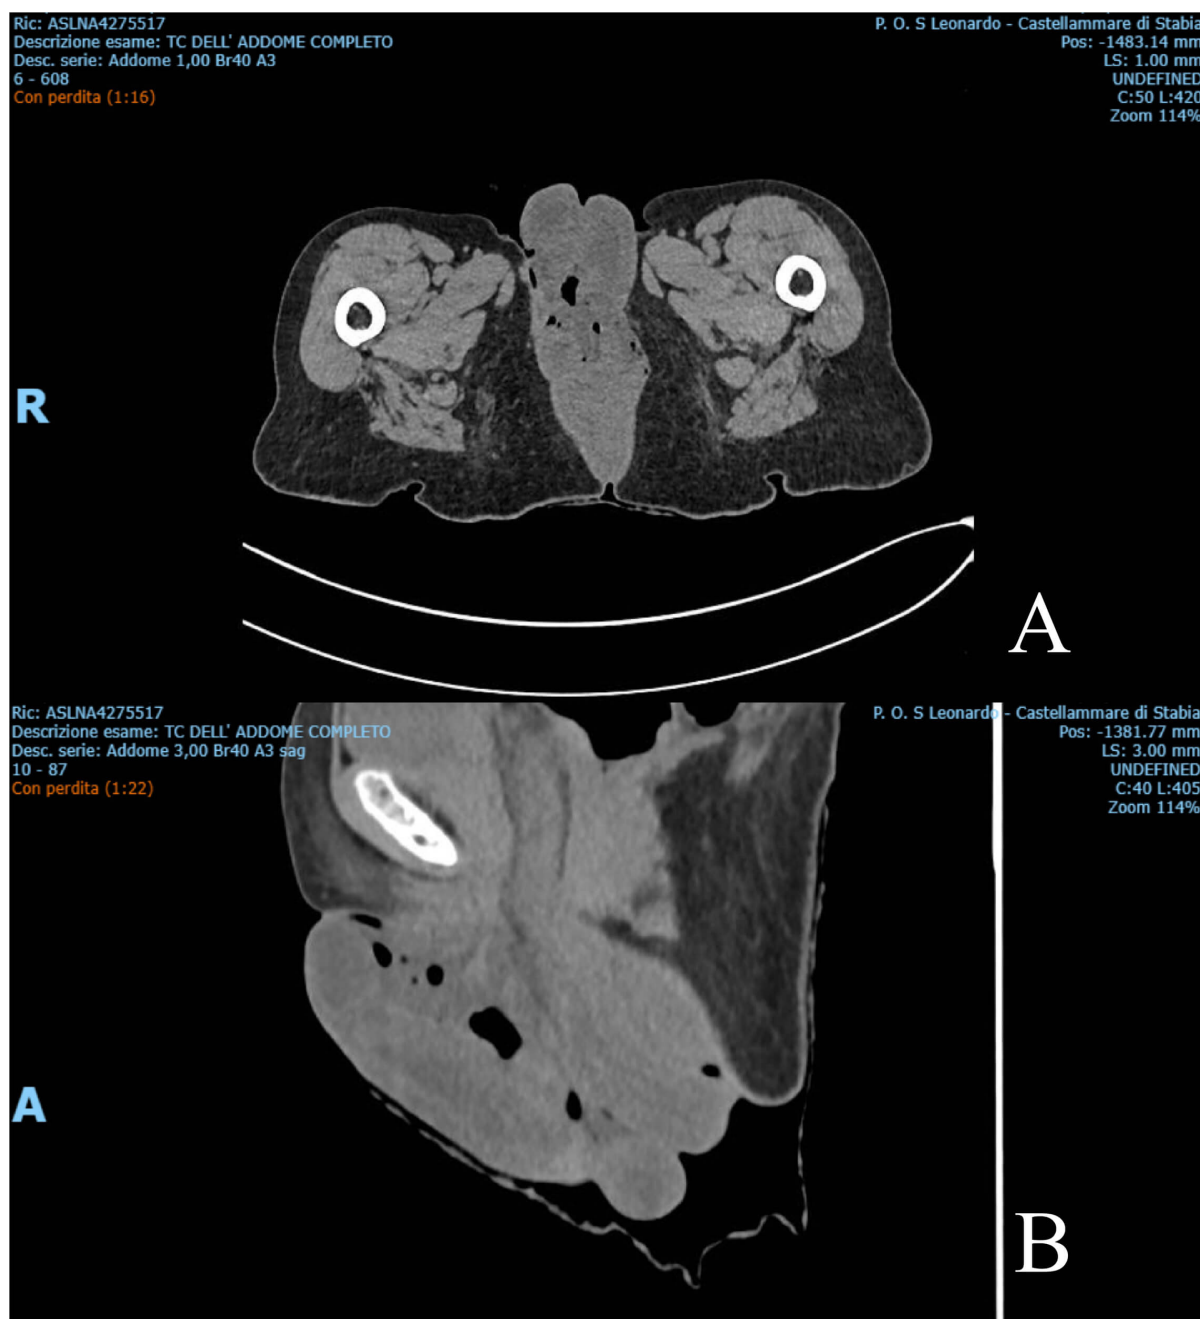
Contrast-enhanced computed tomography showing transvaginal herniation of small bowel loops. (A) Axial view demonstrating herniation of edematous small bowel through the vaginal canal. (B) Sagittal reconstruction confirming transvaginal protrusion of small bowel loops beyond the vaginal introitus.
